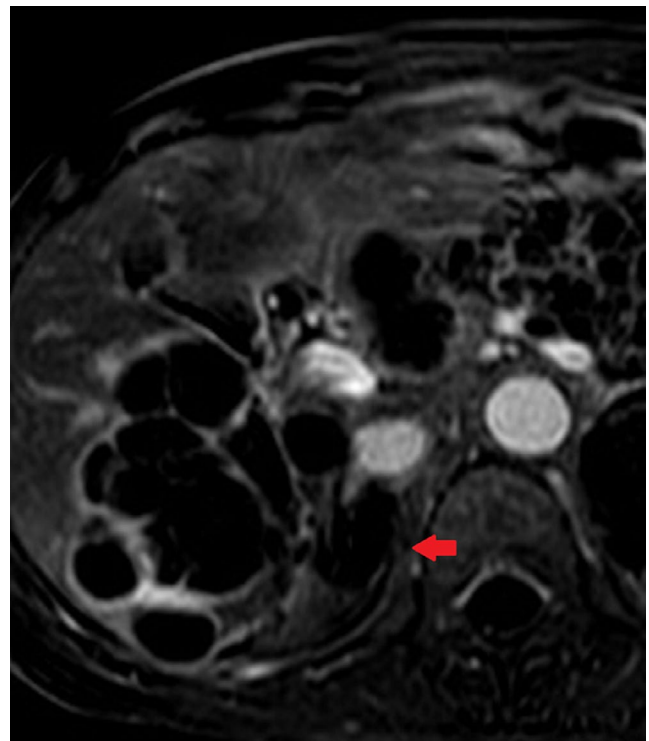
Contrast-enhanced MRI axial image. Axial contrast-enhanced MRI acquired 6 months after combination therapy shows an absence of enhancement in the region of the adrenal tumor (arrow). Tumor size has decreased to 2.3 cm in maximum diameter
